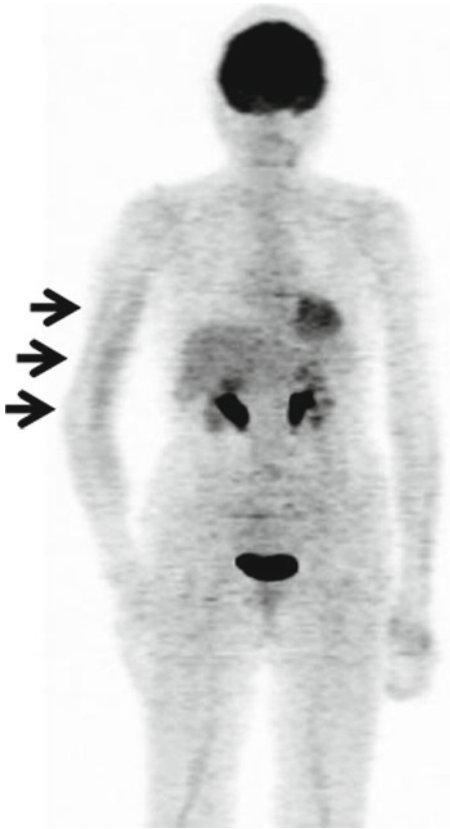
Patient with previous radiotherapy to the right arm for malignant fibrous histiocytoma. MIP image of FDG PET shows increased uptake at the right arm (arrows). This abnormal uptake is a result of postradiotherapy inflammation
